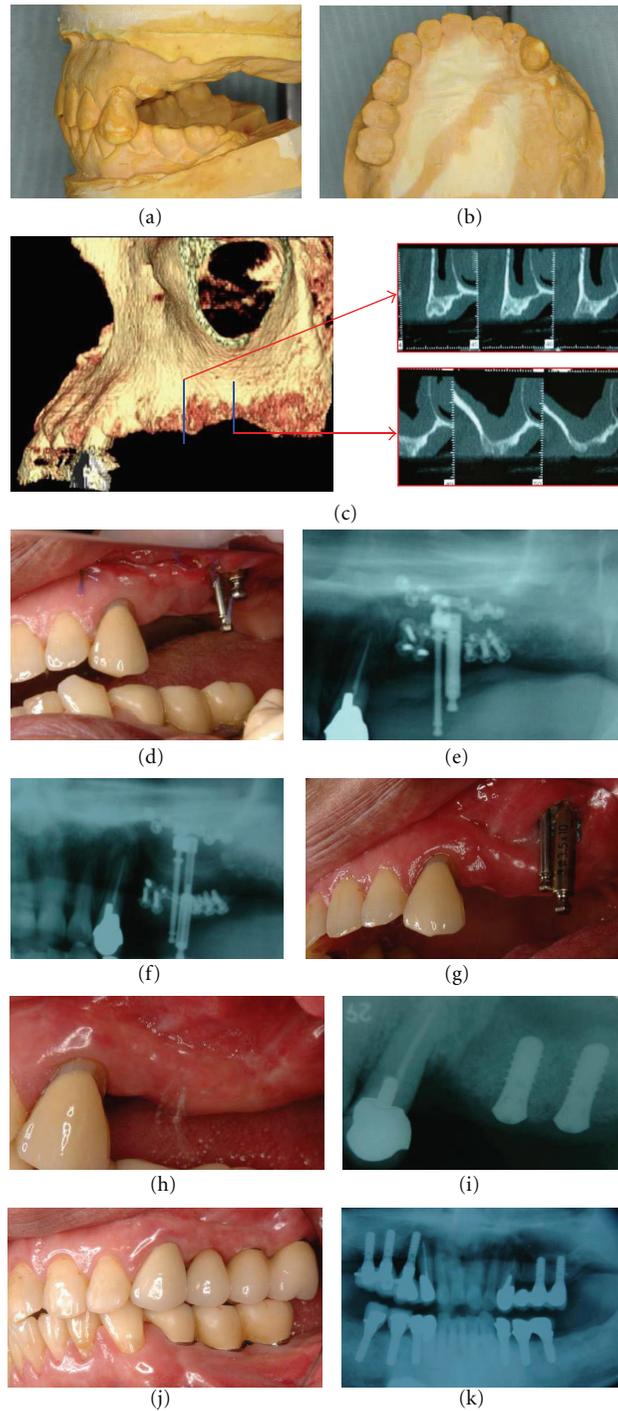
Representative case of unilateral sinus lifting and simultaneous unilateral alveolar distraction for a unilateral partially edentulous, severely atrophic posterior maxilla (Case 5, Table 2). (a, b) Preoperative plaster models of the left posterior maxillary atrophy; (c) preoperative CT views; (d) postoperative intraoral view; (e) postoperative X-ray before activation of distraction with unilateral sinus lifting and simultaneous alveolar distractor setting; (f) postoperative panoramic X-ray after the end of distraction; (g) after the end of vertical distraction; (h) at the time of implant placement and 3 weeks after distractor removal for soft tissue healing; (i) dental X-ray after implant placement; (j) the definite prosthesis was placed after 1 year of provisional restoration as the postloading period; (k) panoramic X-ray taken after 2 years.
